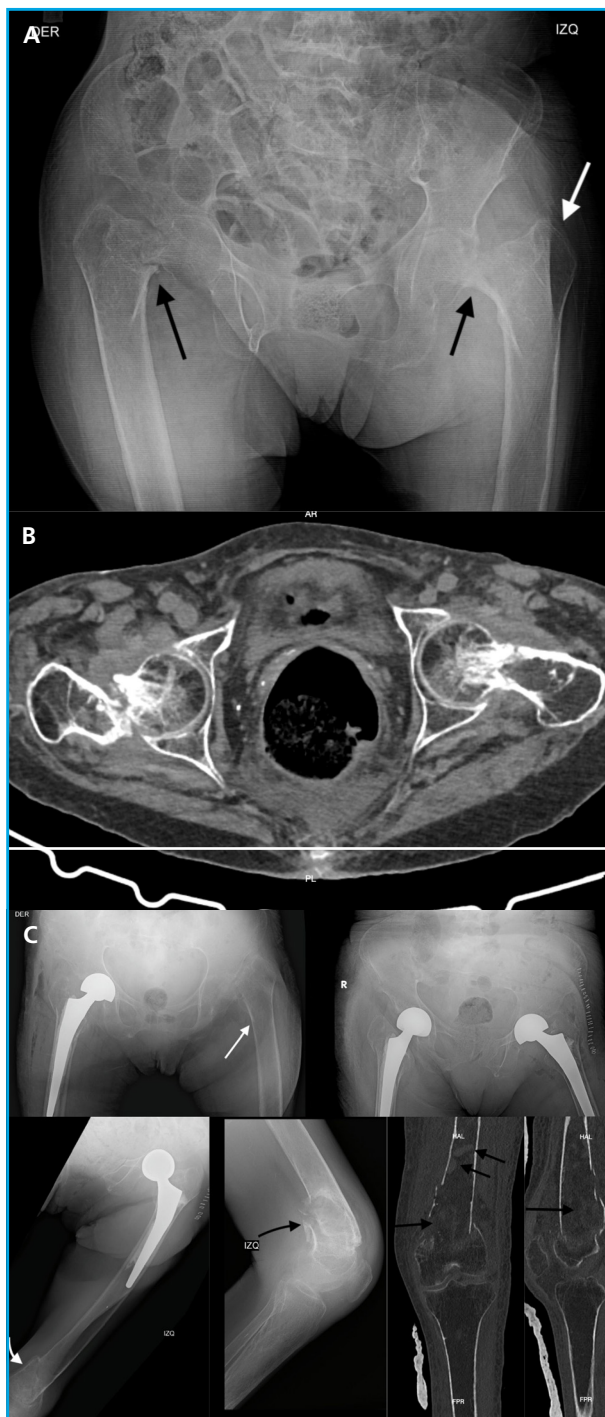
Panel A (upper): anteroposterior plain X-ray of the pelvis. Old fracture in the left femur and signs of callus formation with varus deformity. Transcervical intracapsular fracture of the right hip (Garden III) with an osteolytic lesion in the greater trochanter of the left femur. Panel A (lower): axial CT scan of the hip. Transverse section. Panel B (upper left): plain X-ray of the pelvis with a total right hip replacement. Transcervical refracture of the left hip. Panel B (upper right): bilateral hip replacement. Panel B (lower left): lateral plain X-ray of the knee showing lytic lesions. Panel B (lower right): transverse section of an axial CT scan of the knee.
